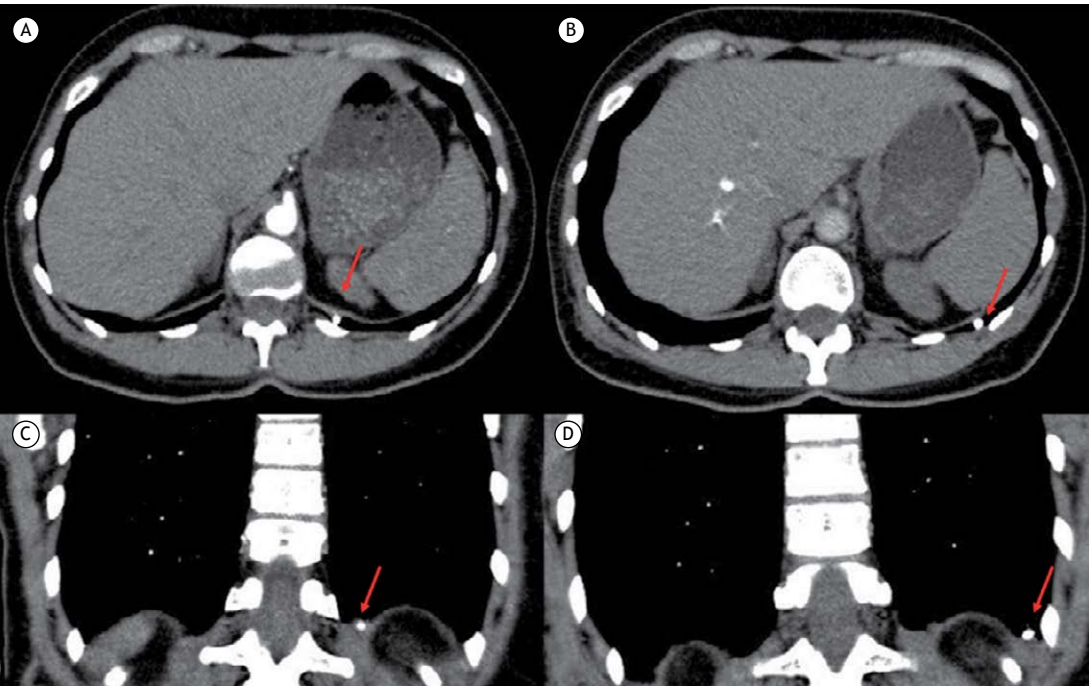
Axial (A and B) and coronal (C and D) CT scans with mediastinal window settings of a male patient with a mobile calcified nodule (arrows) in the pleural surfaces. Note the different position of the nodule on the two axial views and on the two coronal reconstructions.
